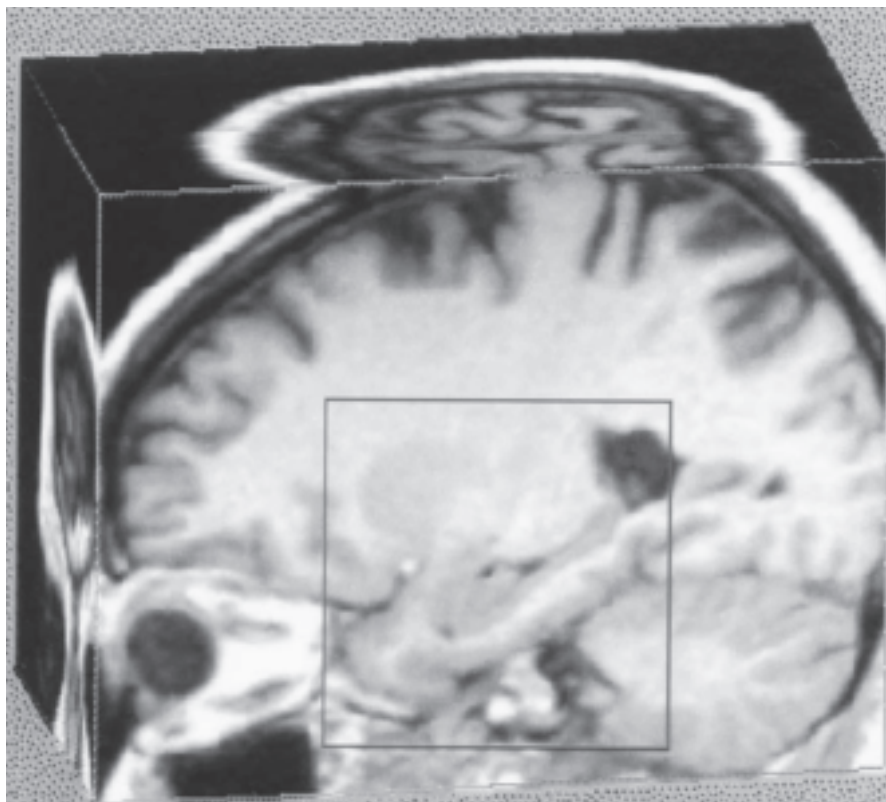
Magnetic resonance images (*left*) can be used to measure the volume of a person's hippocampus (*the hook-shaped structure in the middle*). Yvette Sheline and her colleagues at Washington University used this technique to compare left and right hippocampal volumes in pairs of matched subjects (*above*), in which one suffered from clinical depression (*red*) and the other was a control (*blue*). Despite having comparable total cerebral volumes, the depressed subjects had smaller left and right hippocampal volumes in nearly all cases. As a result, the average hippocampal volumes for control subjects (*blue boxes on vertical error bars*) exceeded those for depressed subjects (*red dots on vertical bars*) on both the left and right sides of the brain. (Image courtesy of Yvette Sheline.)
